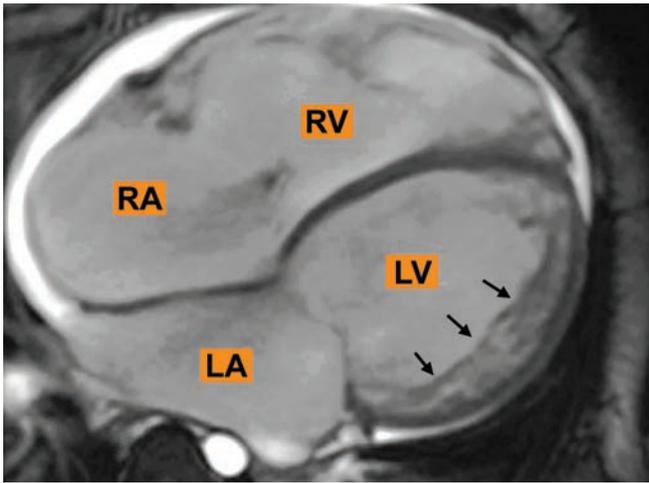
MRI. Cine gradient echo 4-chamber, showing significant dilatation of the four cardiac chambers with hypertrabeculation of LV anterolateral and apical walls. Arrows point to multiple trabeculations consistent with LV non-compaction. Also pericardial effusion is observed. (RV: Right ventricle; RA: Right atrium; LV: Left ventricle; LA: Left atrium).
